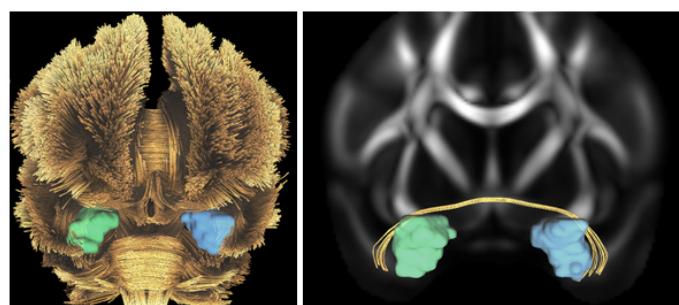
Frontal coronal view of fiber tractography generated using DSI Studio from the Human Connectome project DT MRI data. (a) Full brain fiber tractography with right (green) and left (blue) amygdala shown inside, and (b) Amygdala specific fiber connectivity isolated with FA in the background.
